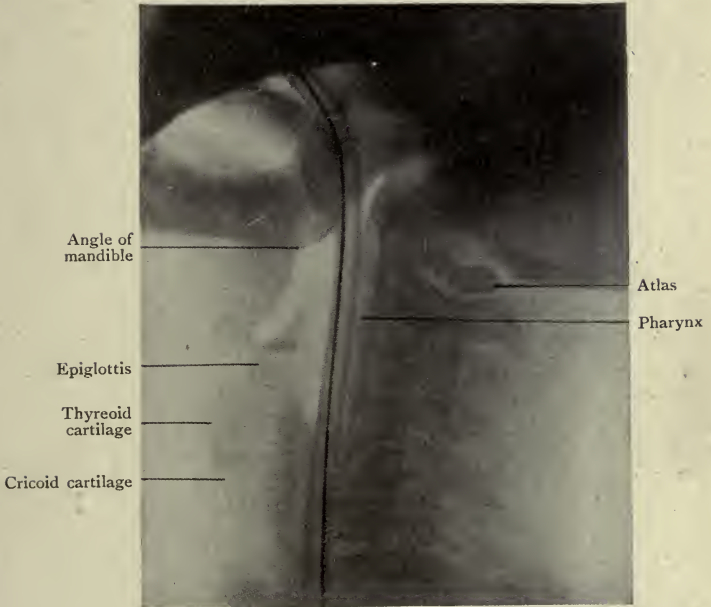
Radiograph of Neck, lateral view, showing the position of the pharynx and œsophagus in which a bougie with a metal core had been inserted. (Gouldesbrough.)
